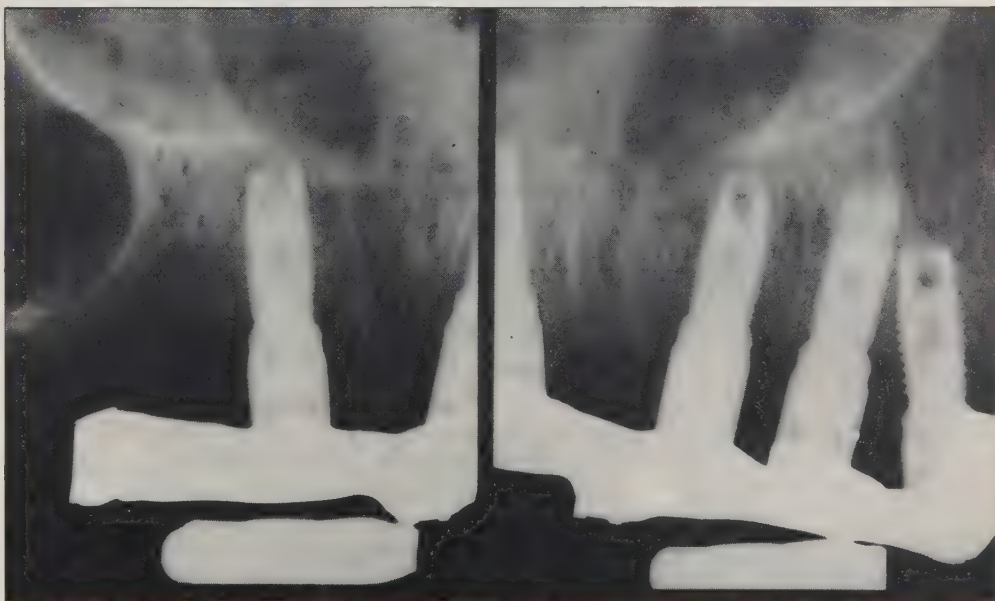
Fifty-two month postoperative radiograph of the four supporting implants.
